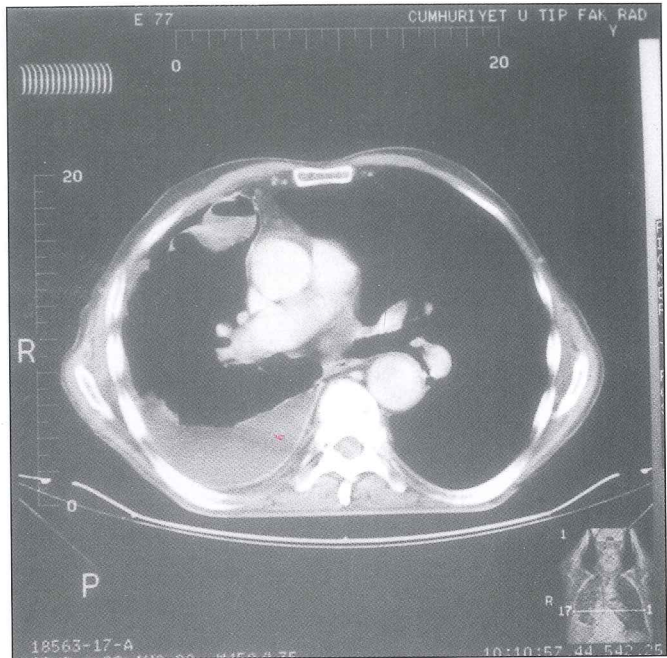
Chest CT demonstrating a cavitary lesion in anterior pleural surface, free pleural surface, free pleural effusion, pleural thickening, and loss of volume in right hemithorax
